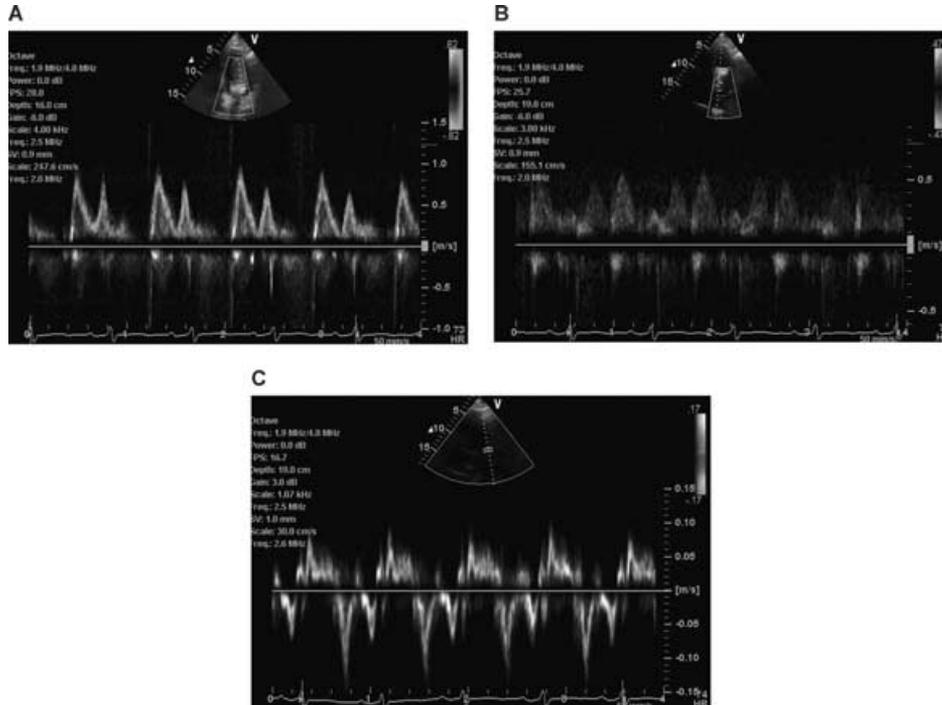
Pulsed-wave spectral Doppler from TTE performed 30 days after RFA showing transmitral inflow (A), left atrial filling (B), and tissue Doppler (C). The ventricular and atrial filling profiles are normal.
